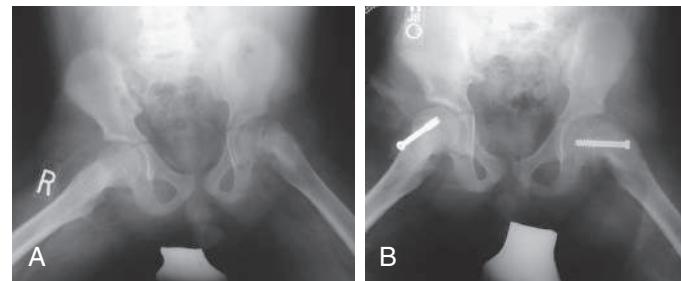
Preoperative (A) and postoperative (B) radiographs demonstrating the in situ pinning in a case of slipped capital femoral epiphysis.
